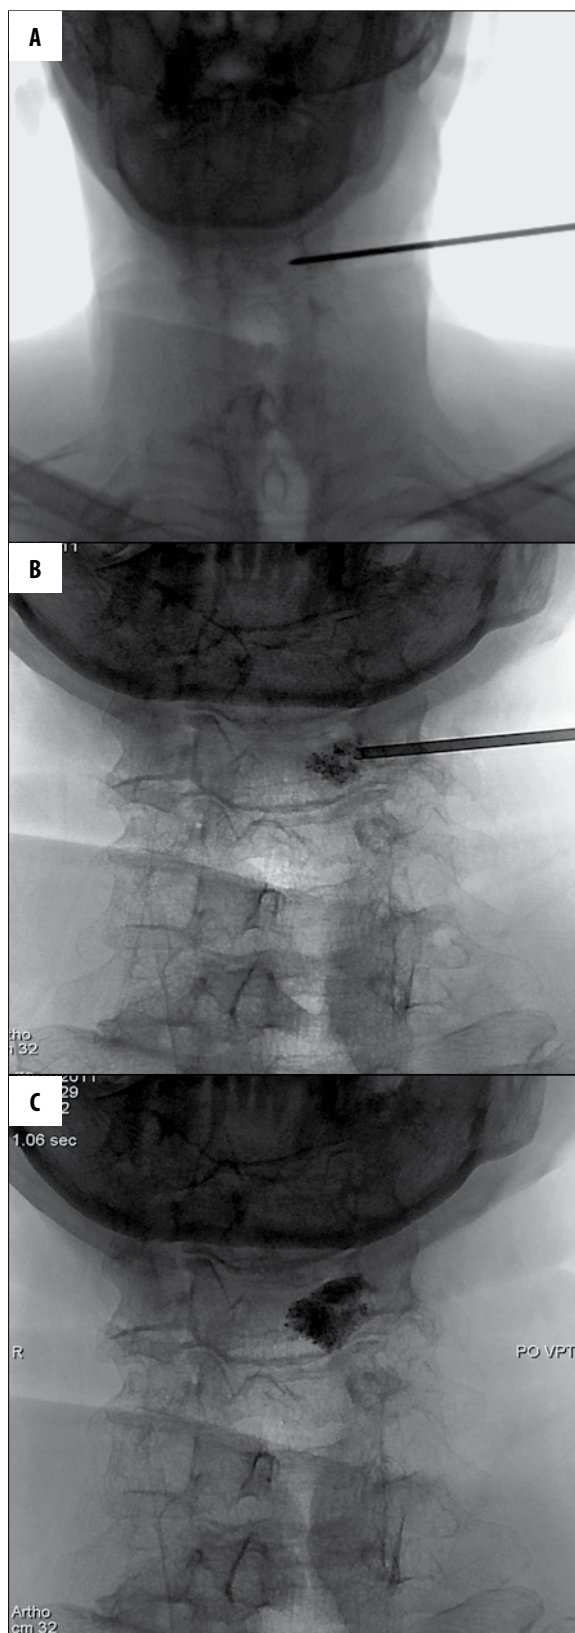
(A) X-ray-guided C4 vertebroplasty – during the procedure. (B) During the procedure – administration of PMMA cement. (C) After the procedure. Pathological fracture of C4 vertebral body due to nonresectable, malignant tumor of piriform recess.
